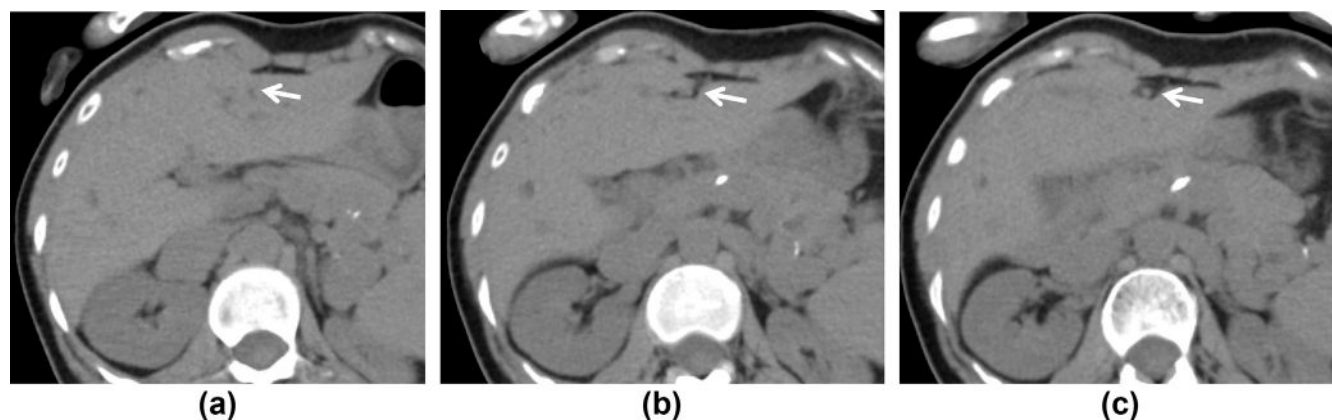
A 47-year-old woman with fusion of the left lobe and quadrate lobe of the liver. Unenhanced axial CT images of the abdomen show the hypoplasia of the fissure for ligamentum teres (arrows). In this case, the function and size of the liver was normal, and anomaly in the biliary system is not seen.
